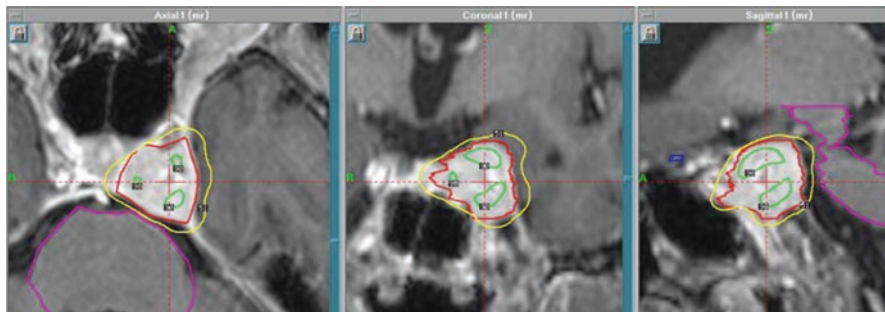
Gamma knife planning for pituitary adenoma involving the left cavernous sinus. Axial, coronal, and sagittal views on T1-weighted MR scans. The 50% isodose line covers the lesion completely
